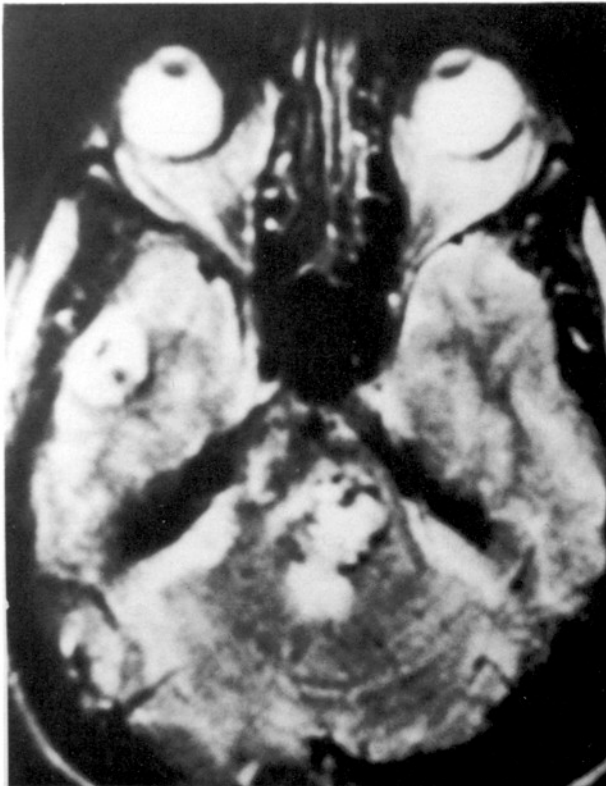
Axial magnetic resonance scan in 1990; there are multiple lesions with decreased signal intensity compatible with calcifications and lesions in the brainstem and left temporal region are well circumscribed with a core of mixed signal intensity on T2-weighted image.
